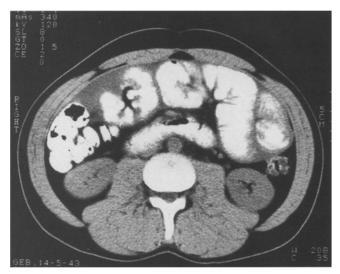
CT scan of the abdomen, showing intestinal obstruction at 22 months after treatment with i.p. mitoxantrone. The scan shows thickened bowel walls and dilated small-bowel loops
